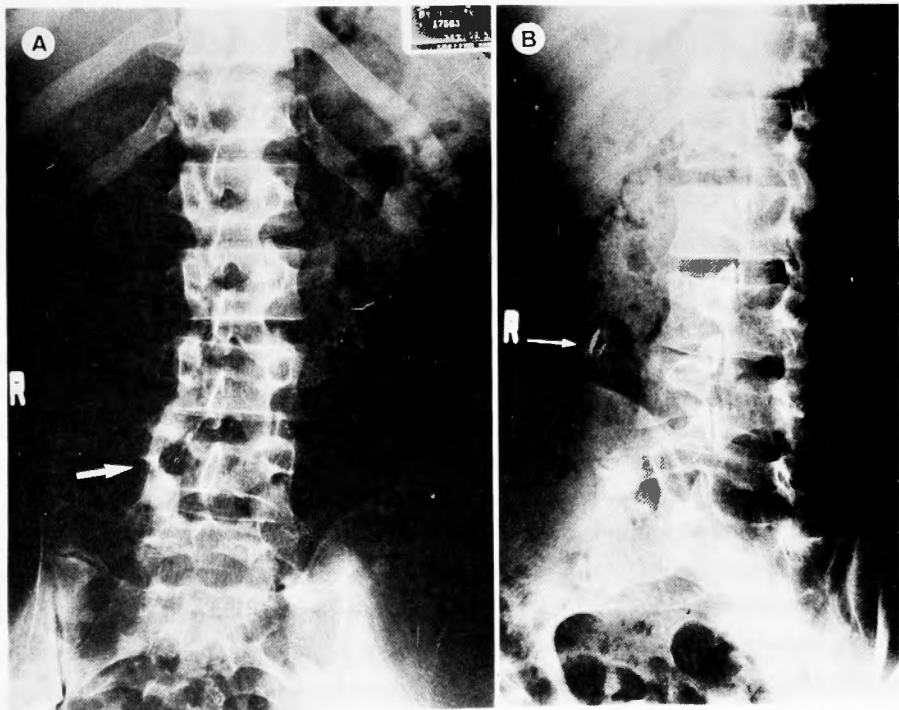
Plain roentgenograms in anteroposterior view (A) and right posterior oblique view (B). Arrows in A and B show fracture of the 4th vertebra and a free bone fragment, respectively.
